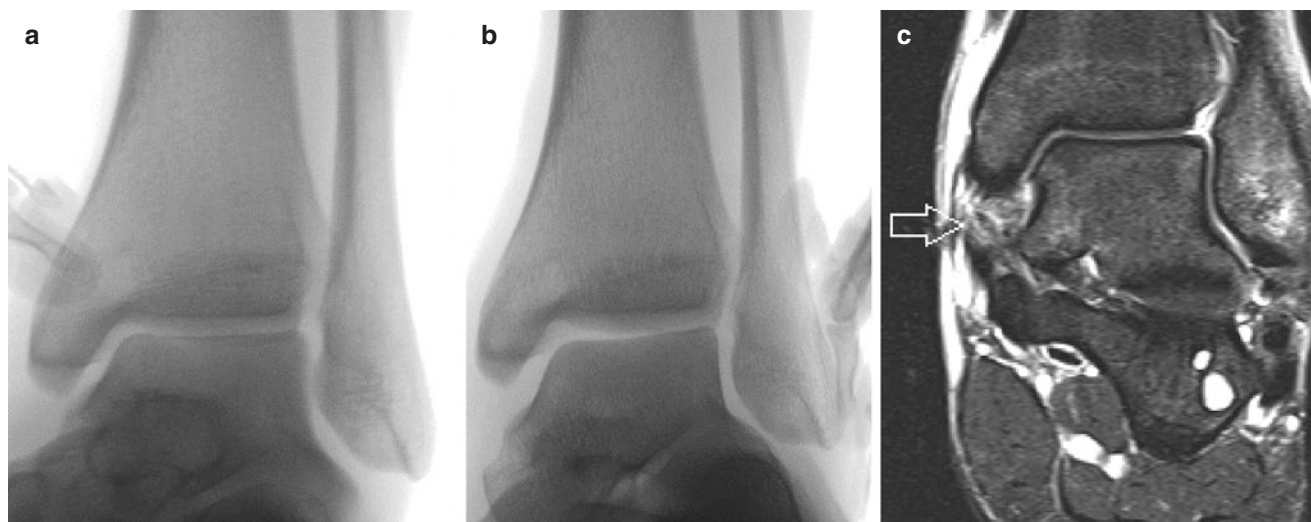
(a) Anterior-posterior radiograph of left ankle in non-stressed position. Note normal appearing alignment, including normal medial clear space. (b) Stress antero-posterior Radiographs of the same left ankle noting mild talar tilt and increased widening in the medial
